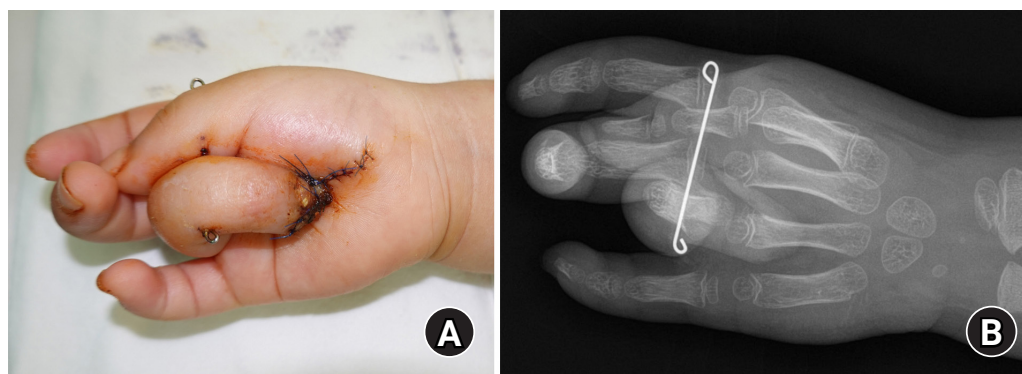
(A) Immediate postoperative photograph after applying a Kirschner wire between the shafts of the ring finger middle phalangeal bone and the thumb proximal phalangeal bone to prevent movement of the flap. (B) Postoperative X-ray.
